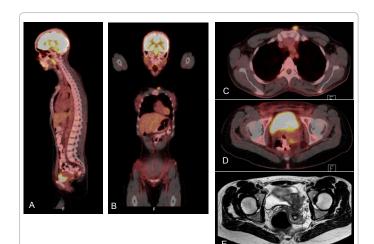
A PET/CT scan of the 34-year old patient 3 weeks after the robot-assisted pelvic lymphadenectomy. A parasternal hotspot appeared to be a atheroma cyst. The pelvic lesion was thought to represent the adenocarcinoma of the cervix or the PEComa.
